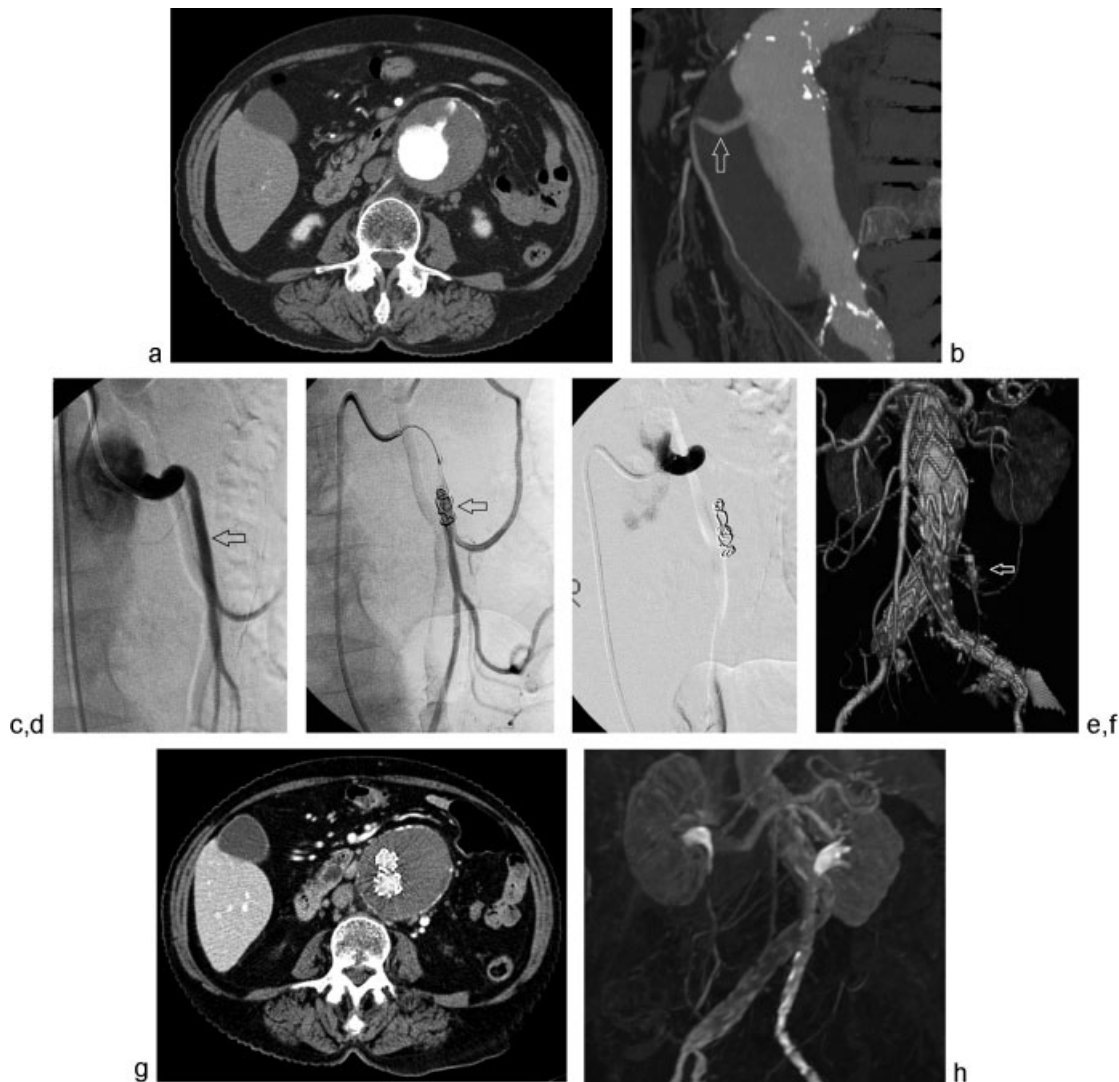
Axial CT angiogram (a) demonstrates a large infrarenal AAA with a widely patent IMA. 3D CT angiogram reconstruction (b) re-demonstrates a patent IMA (arrow). Pre-EVAR angiogram (c) demonstrates a patent IMA (arrow). Platinum coils were deployed with intermittent angiography (arrow) (d) until complete IMA stasis was achieved (e). CT angiogram 3D reconstruction (f) obtained 1 month post-EVAR demonstrates occlusion of the IMA (arrow) and absence of endoleak. Surveillance CT (g) and MR (h) angiogram, obtained at 2 and 3 years postoperatively, again demonstrate freedom from type 2 endoleak or sac enlargement.
